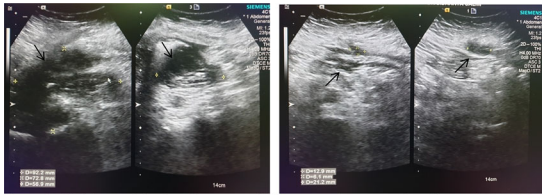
A) Initial ultrasound showing a large mass with inhomogen echostructure. B) Follow up ultrasound showing reduced size of the mass 3 weeks after antibiotic therapy
